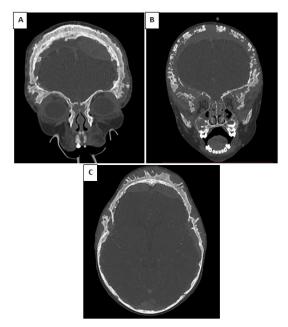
Cerebral CT scan without contrast injection (Bone window): (A) coronal section: bi-parietal bone thickening. (B) Coronal section: diffuse osteolytic bone lesions at the level of the cranial vault and the base of the skull. (C) Axial section: Bifrontal grass fire periosteal reaction.
